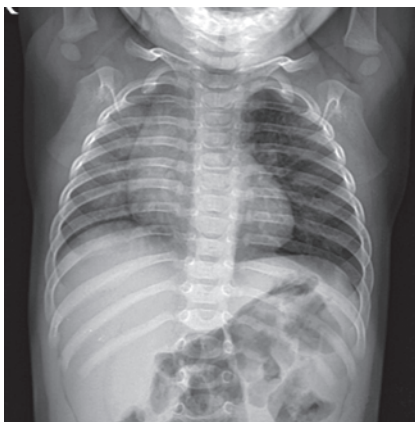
X-ray chest: Left obstructive emphysema due to radiolucent foreign body
